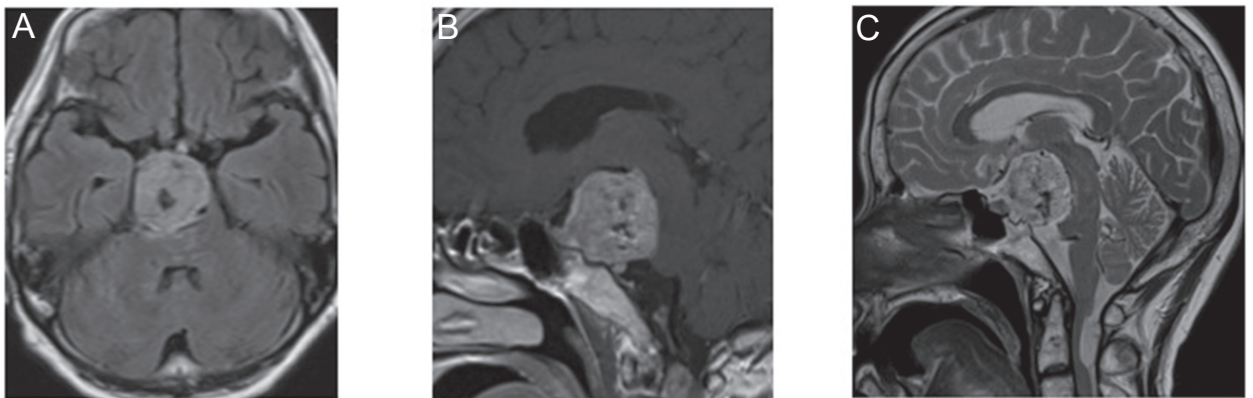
A: Preoperative T₁-weighted axial magnetic resonance imaging (MRI) with gadolinium reveals homogenous enhancement of the midline clival lesion. B: Preoperative T₁-weighted sagittal MRI with gadolinium shows the lesion bending the brain stem. C: Preoperative T₂-weighted axial MRI demonstrates no remarkable perifocal edema.
